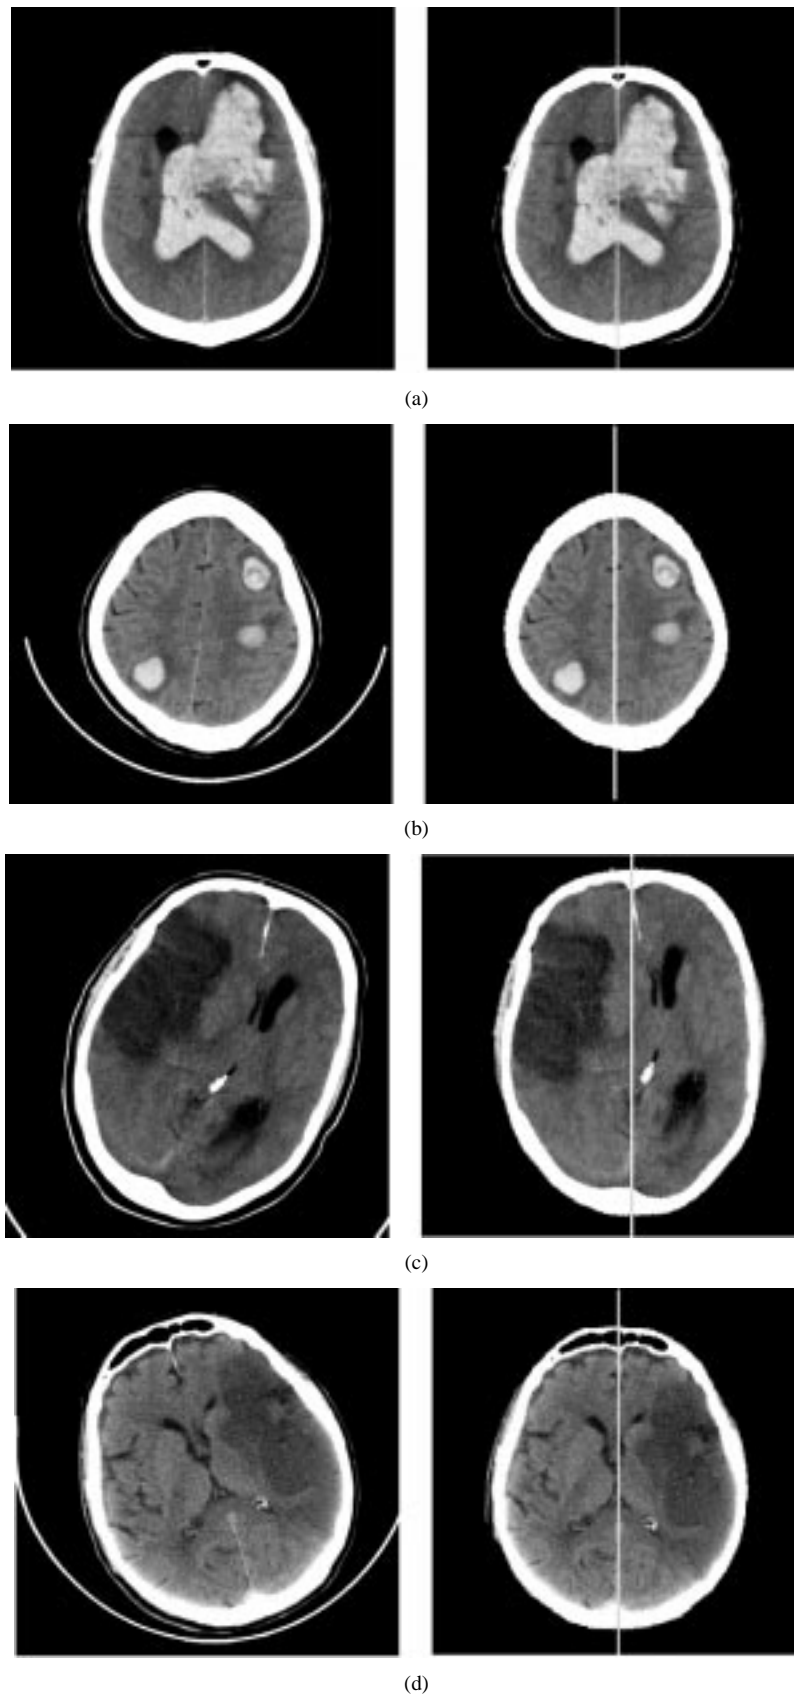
The symmetry axes extracted from different clinical CT scans where obvious asymmetry is present. (a) Acute blood (left frontal), (b) multifocal acute blood (left frontal and right parietal), (c) infarct (right frontal), and (d) infarct (left frontal and temporal).
